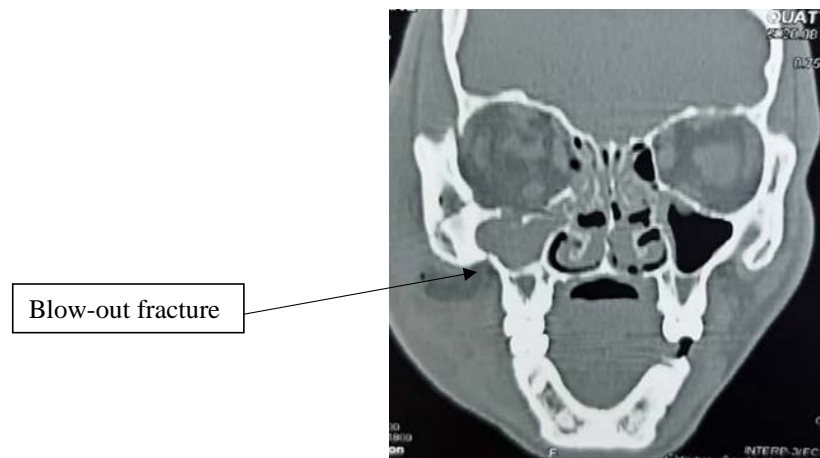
CT scan, frontal section. Blow-out fracture of the right orbital floor.
